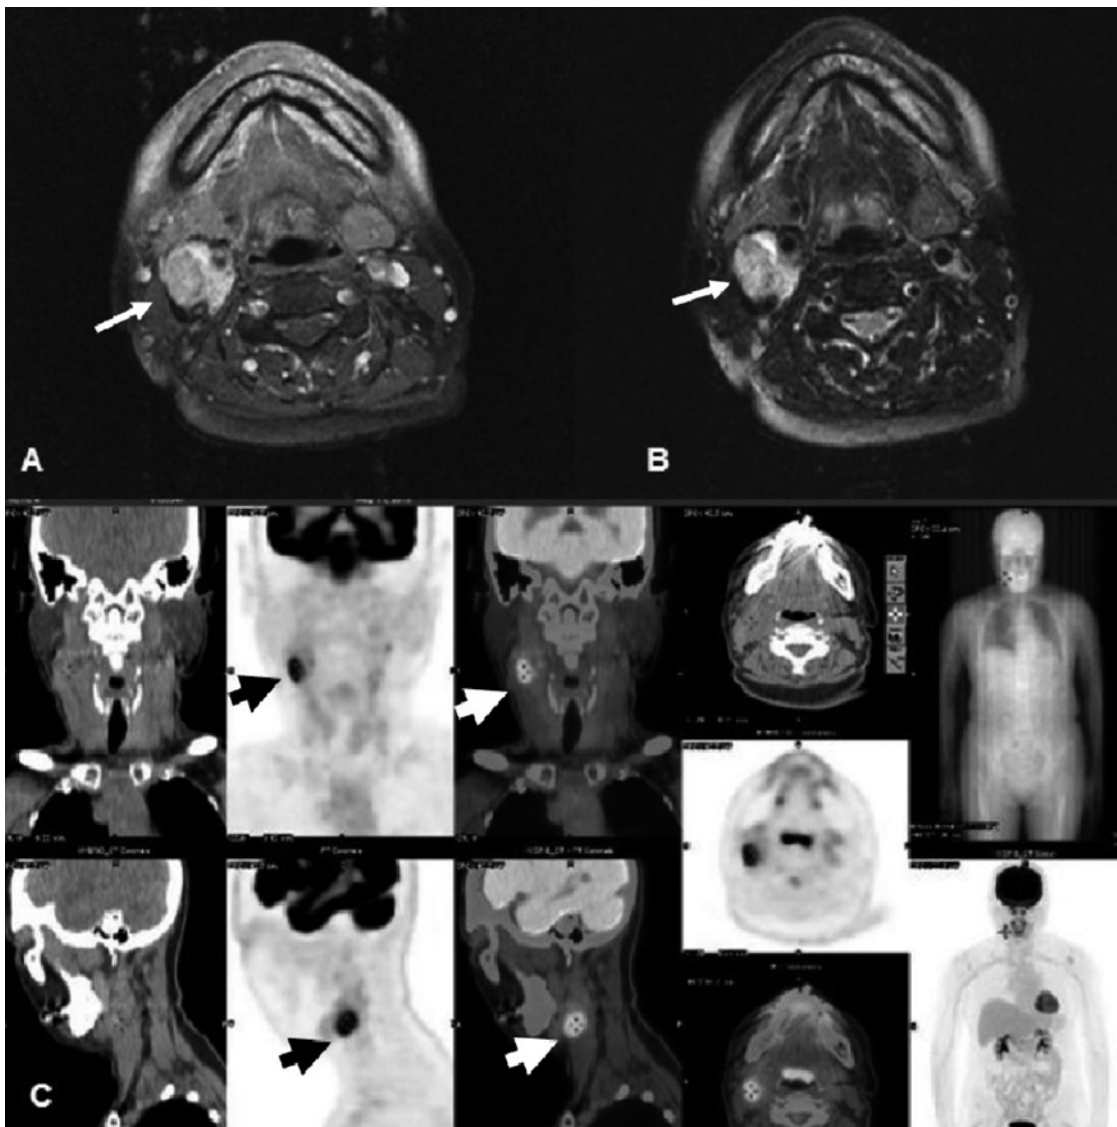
Neck MRI showed a well-defined tumor (A & B, arrow), and FDG-PET showed higher standardized uptake value (SUVmax, 8.4).
